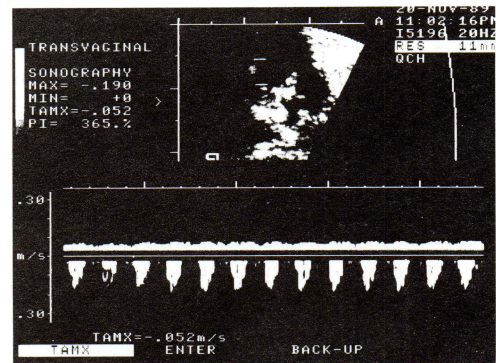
Doppler umbilical artery velocity waveforms at 9 weeks gestation demonstrate physiologic absent end-diastolic frequencies (lower channel).
